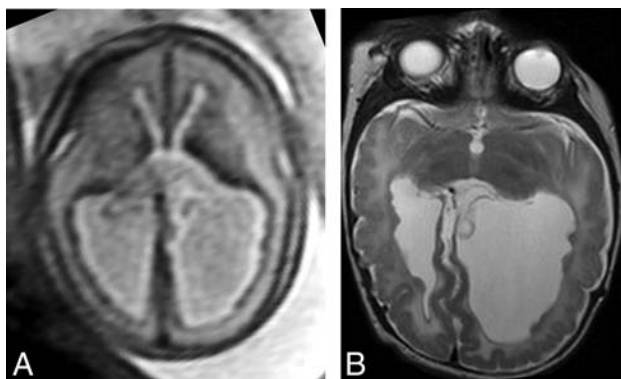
Example of SEH prospectively diagnosed on fetal MR imaging (true-positive finding). Axial T2 single-shot fast spin-echo imaging of the fetal brain at 25 weeks' GA (A) demonstrates multiple nodules along the ependymal surfaces of the lateral ventricles suspicious for SEH. Postnatal brain MR imaging at 5 weeks of age (B) confirms the presence of bilateral SEH on axial T2 FSE.
